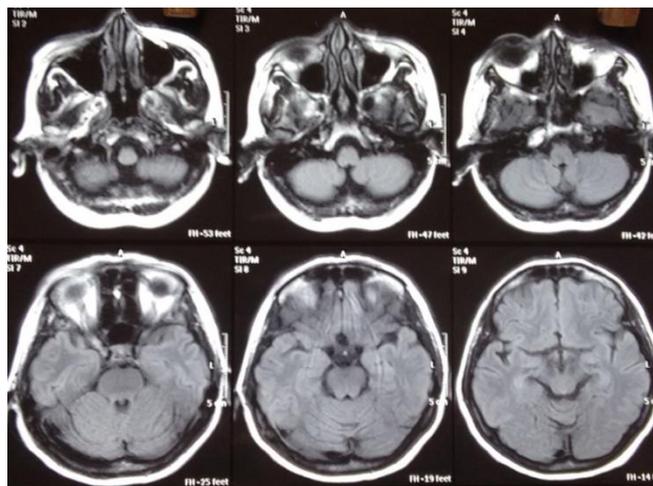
MRI; axial plane-shows diffuse soft tissue enhancement and stranding of retrobulbar fat with post contrast enhancement of the right orbit.
